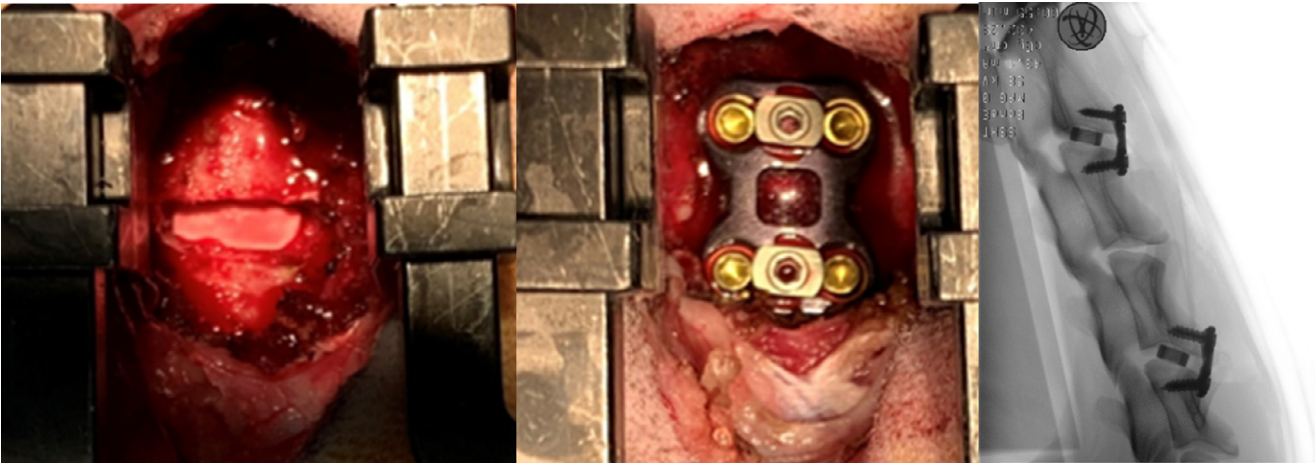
C2/3 Implantation of test article prior to applying supplemental fixation (left), final implantation including supplemental fixation prior to site closure (centre), radiograph of C2/3 and C4/5 implantation sites (right).
